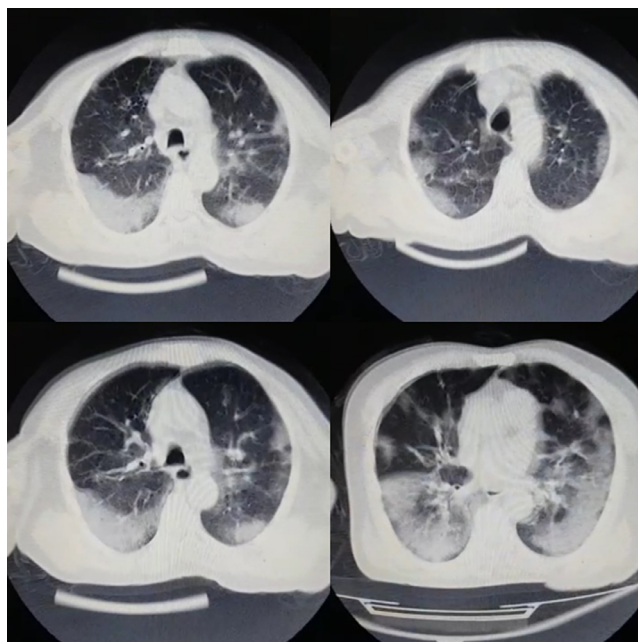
The computed tomography-scan of the patient, showing round-glass opacities in the lung.
